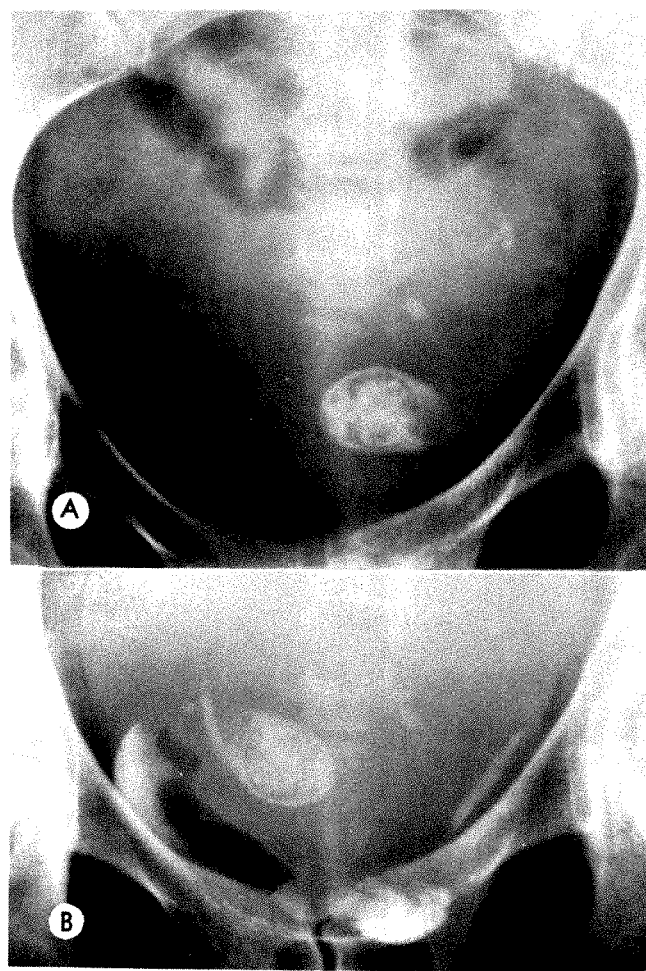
A, Anteroposterior roentgenogram of pelvis immediately prior to excretory urography. Large calcified opacity lies left of midline within pelvis. B, AP view during urography showing opacity within right portion of pelvis adjacent to opacified right ureter. Opacification of left ureter and bladder also demonstrated.
